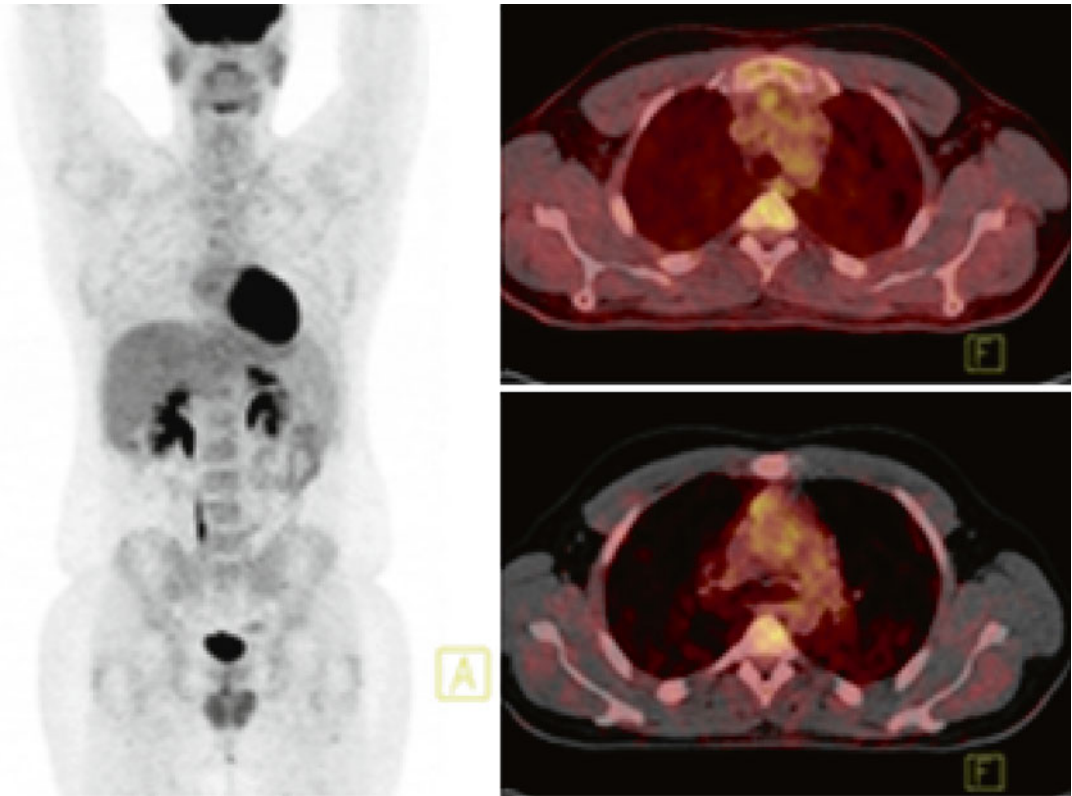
Follow-up PET/CT: two residual hypermetabolic lymph nodes at the upper mediastinum (SUVmax 2.9 and 3.4, respectively), interpreted as D5-PS score 4)
